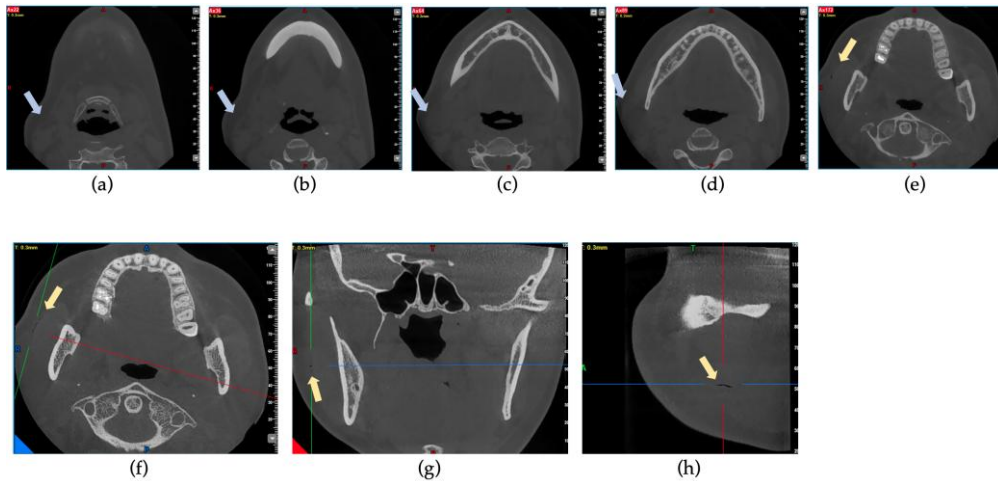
CBCT scans obtained after emphysema developed. (a)~(e) Coronal views of the swelling. (f)~(h) An air-filled fissure between the masseter muscle and soft tissue. Blue arrows: swelling. Yellow arrows: the fissure.
